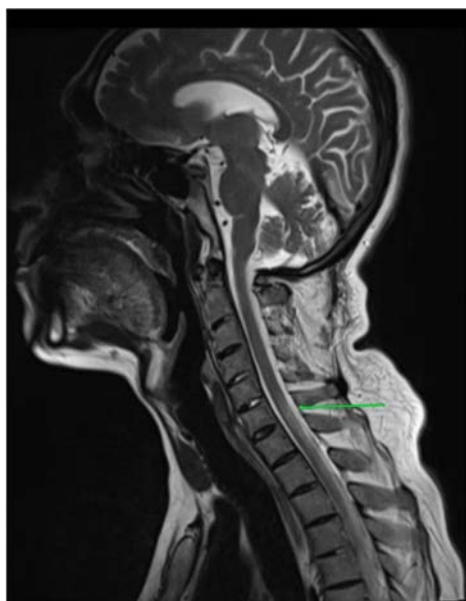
Sagittal T2-weighted MRI spine demonstrating long-segment posterior column T2 hyperintensity (green arrow) beginning at C6 and extending to D7.
